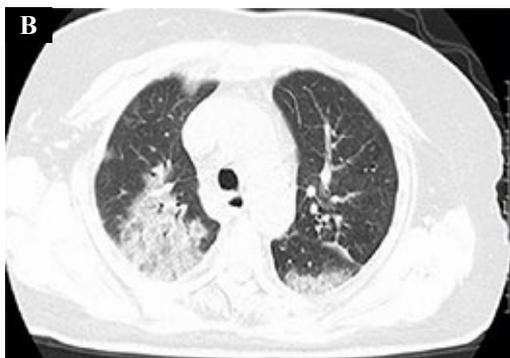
A 79-year-old woman diagnosed with COVID-19 (Courtesy of Song F, Shanghai Public Health Clinical Center, Shanghai, China). Chest radiograph (A) and CT-Scan image (B) obtained on day 4 show airspace consolidation [9].
